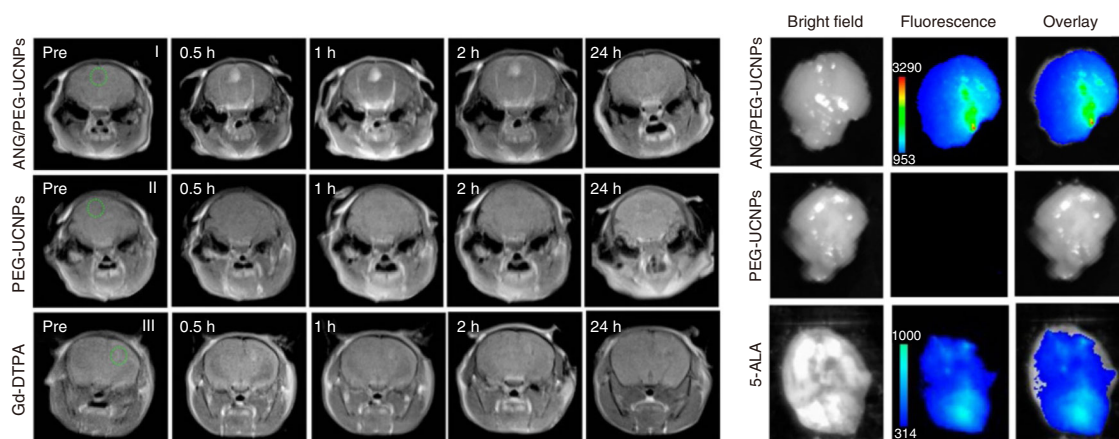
Intravital dual-modal MRI/UCL imaging of brain tumor after injection of ANG/PEG-UCNPs, PEG-UCNPs and Gd-DTPA. Reprinted with permission from ref. ⁷⁶. Copyright 2014 American Chemical Society
